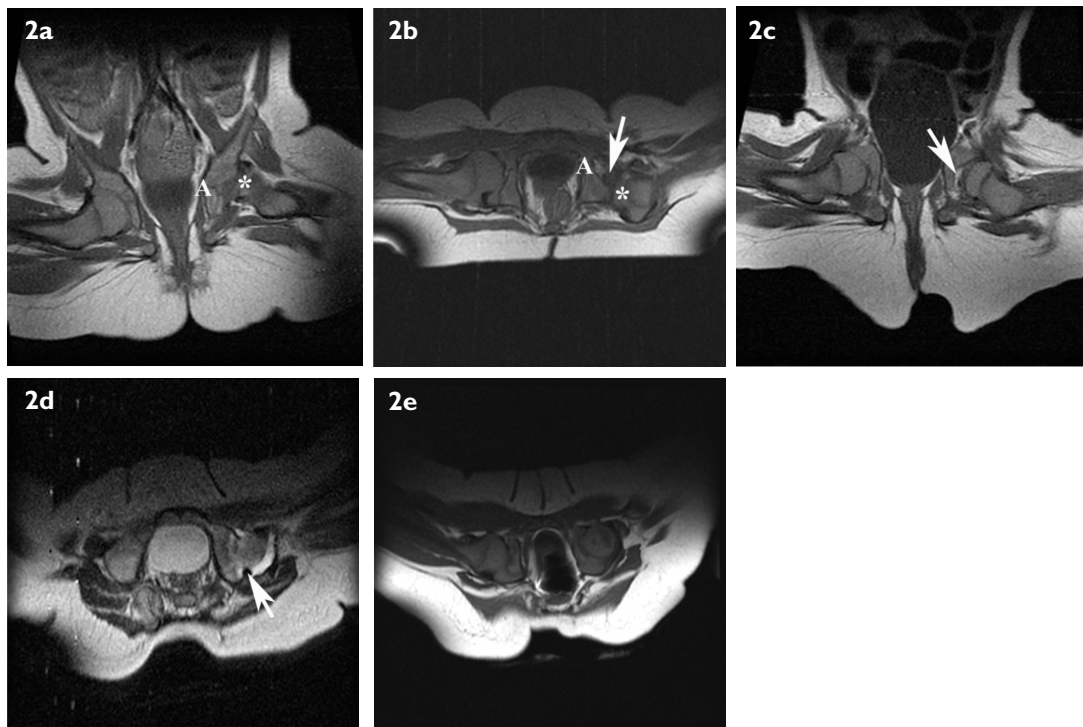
A ten-month-old female infant diagnosed at birth with bilateral hip dysplasia. Successful treatment of the right hip was achieved with a Pavlik harness, but the left hip persisted to be dislocated even after bracing. Closed reduction of the left hip with spica casting was performed using MR imaging guidance. (a) Coronal and (b) axial spin-echo T1-W MR images show the posterosuperiorly dislocated left femoral head (*). The left acetabulum (A) is relatively shallow. On the axial image, low-signal intensity soft tissue is present within the acetabulum presumed to represent inverted labrum and/or elongated ligamentum teres (arrow). (c) Coronal spin-echo T1-W MR image after closed reduction shows that the left proximal femoral epiphysis is now well-centred within the acetabulum, although some fatty tissue remained interposed between the cartilaginous femoral head and acetabulum (arrow). The left femoral head is slightly smaller compared to the right. (d) Axial spin-echo T2-W MR image after closed reduction shows marked joint effusion and a thickened, blunted labrum posteriorly (arrow). (e) Axial spin-echo T1-W MR image performed three months later at a recast procedure in the open MR unit shows that the left proximal femoral epiphysis is deeply seated within and well covered by the acetabulum. The interposing fatty tissue is no longer present. This was the last cast that had to be applied, subsequently followed by a period of bracing. The five-year clinical and radiographical follow-up showed no residual sign of hip dysplasia.
